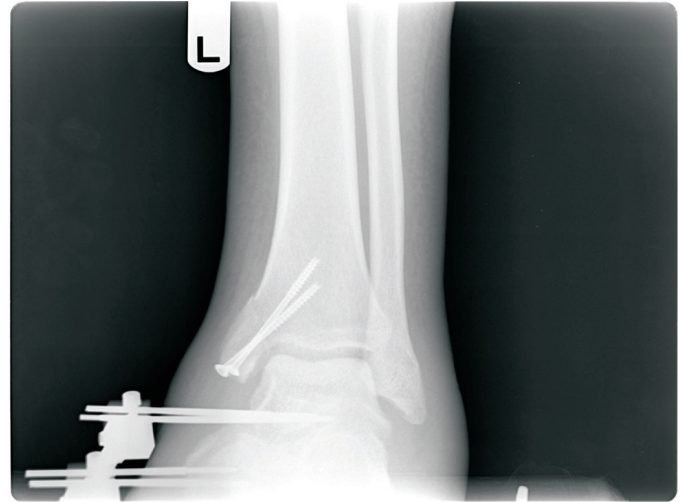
Four weeks postoperative radiograph.
